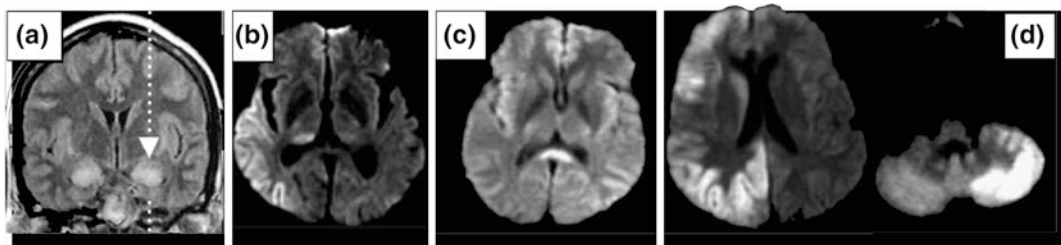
MR images, FLAIR sequences. a Arrow shows left-sided region of change (shown only on the left side for clarity, but bilateral change is present). b Axial DWI showing gyral pattern of restricted diffusion and ipsilateral thalamic (pulvinar) change in a patient with left
